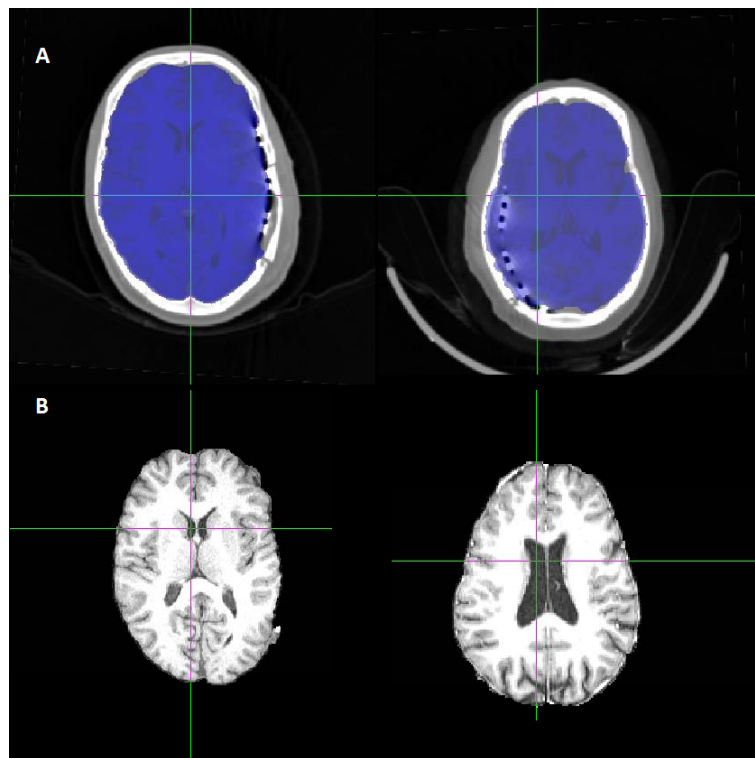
A - CT-MRI co-registration, using FLIRT, (left) in patient 1 and (right) in patient 3; B - T1 image, showing the size of the ventricles, in the corresponding patients.
